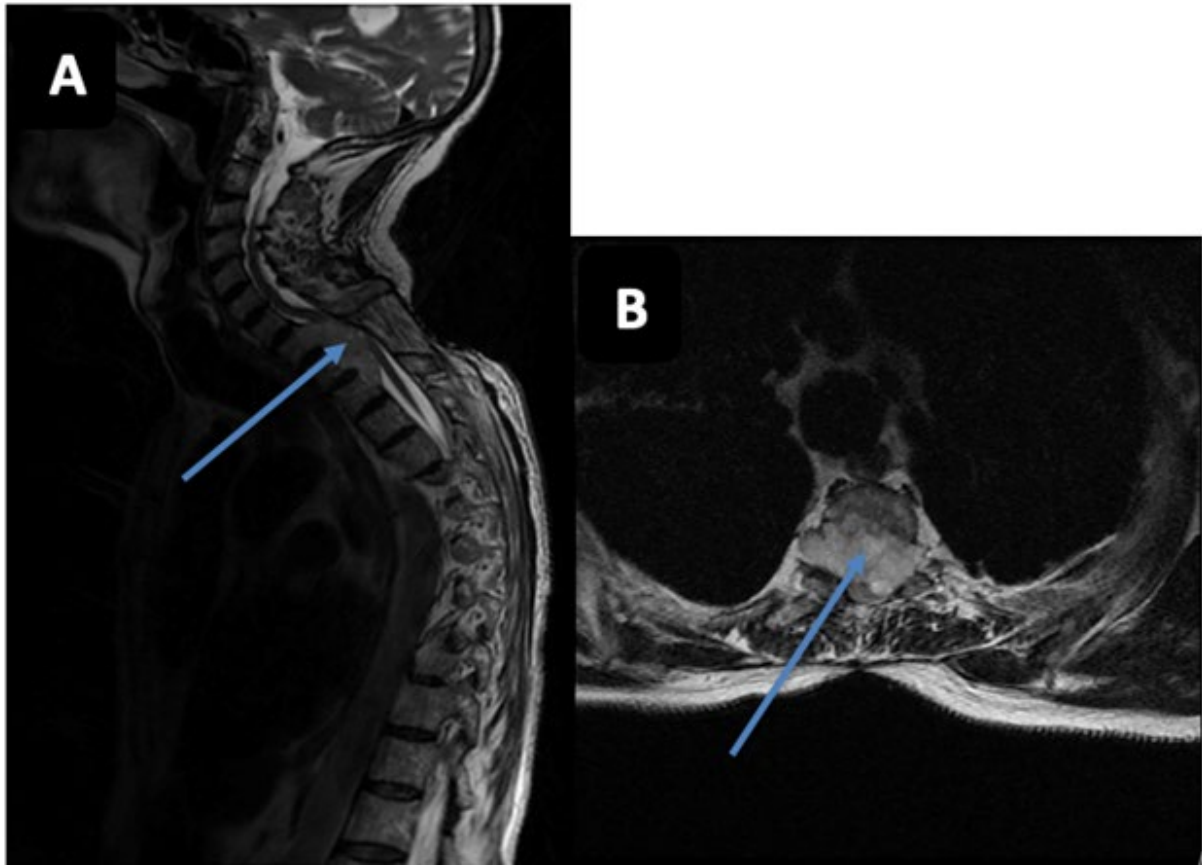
A: MRI Hyperintense Lesion on T2-Weighted Imaging. B: T1-Weighted Lesion Intensively Enhanced by The Gadolinium.
